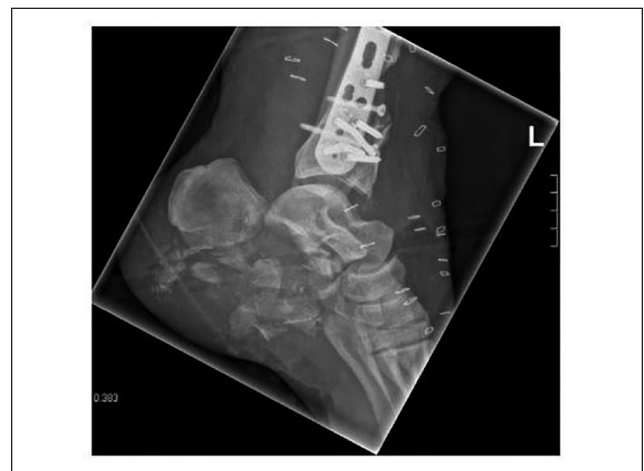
Lateral radiograph of the left calcaneus after transfer to our hospital.
